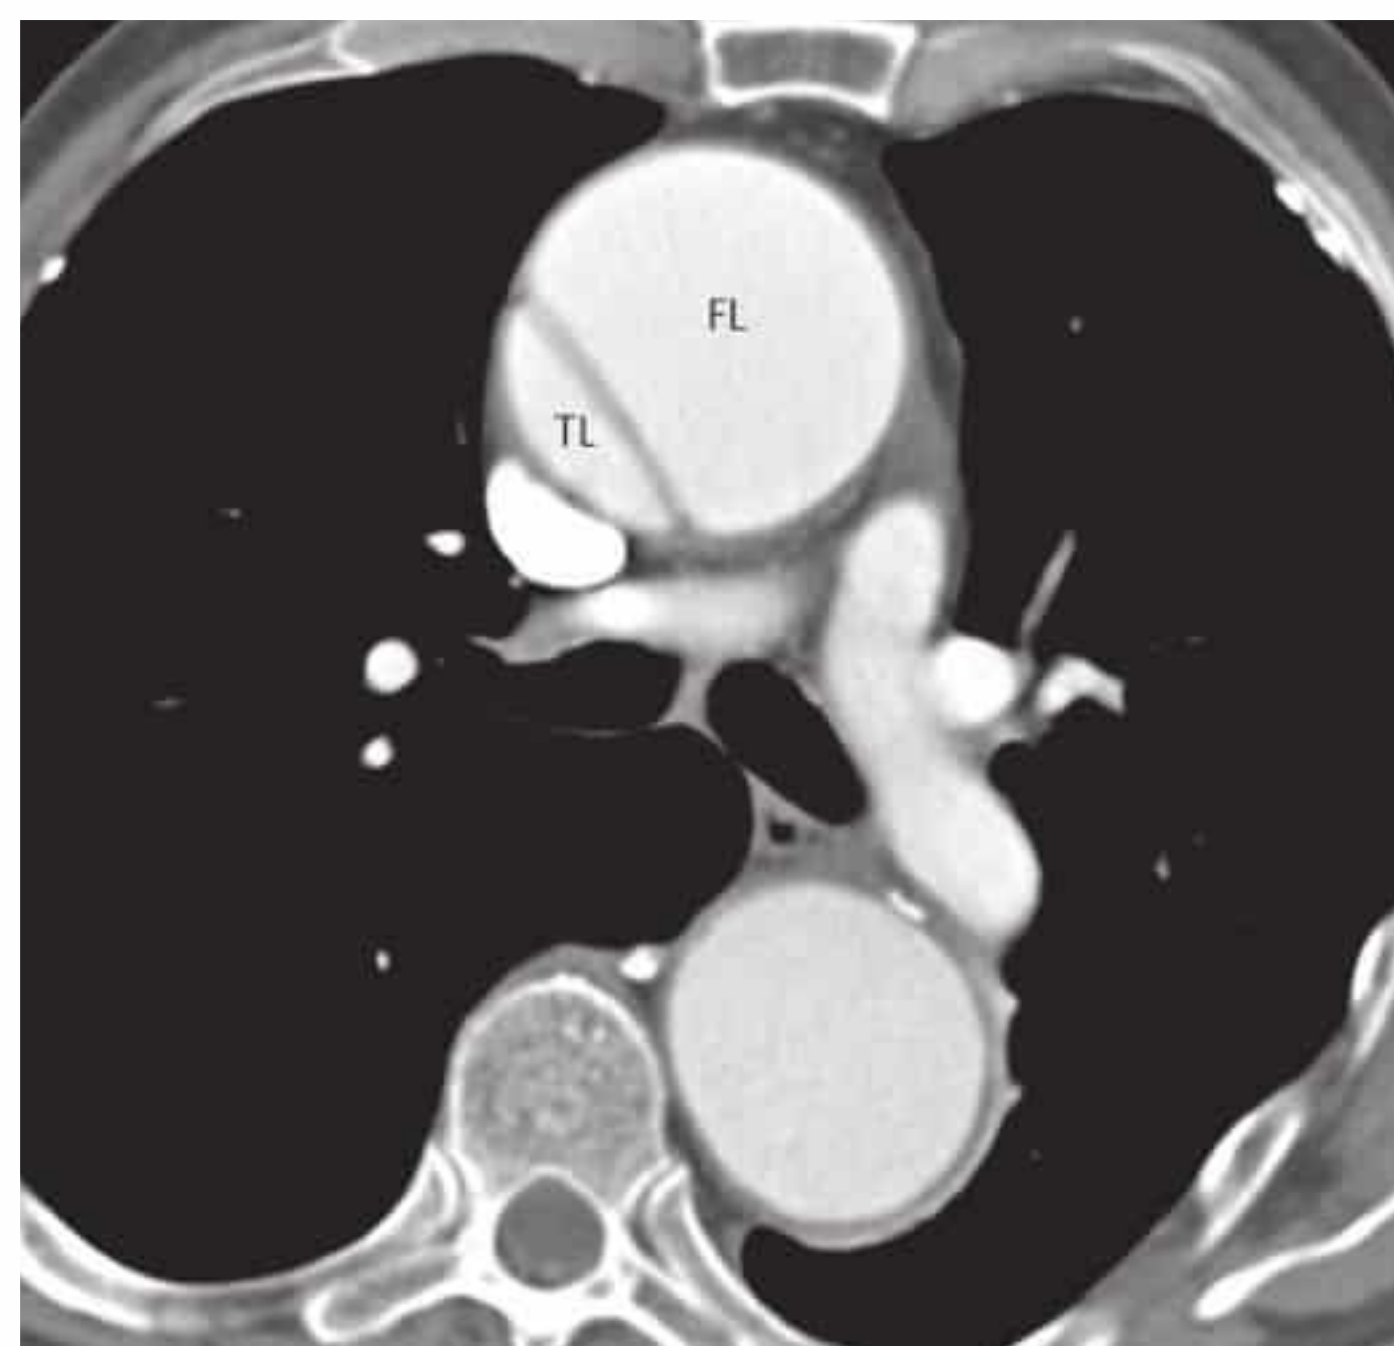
Contrast-enhanced CT of an aortic dissection confined to the ascending aorta (Stanford type A or DeBakey type 2). Dissection is absent in the descending aorta.
